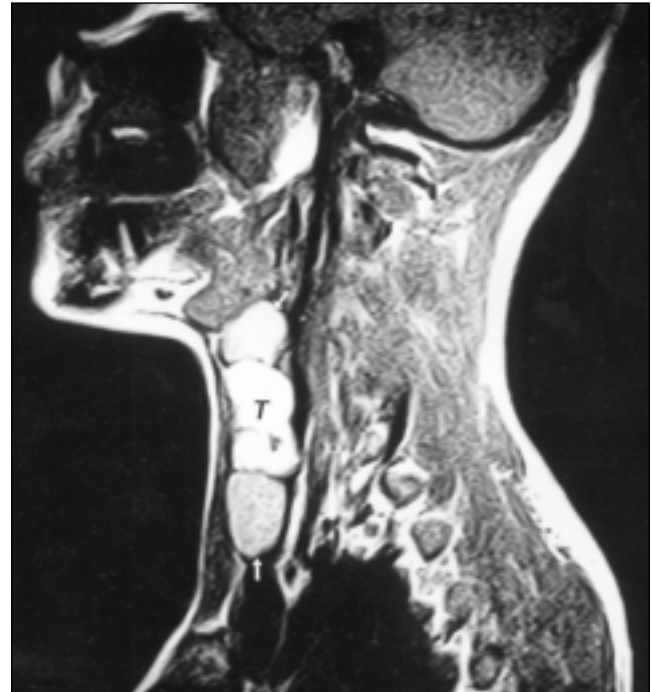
Sagittal MRI scan shows a cystic mass in the left neck.
